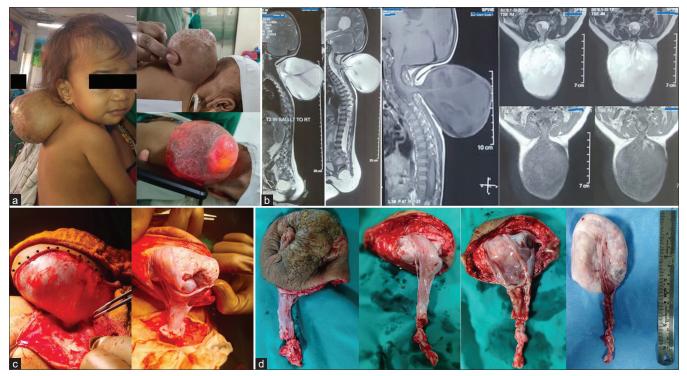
(a) A solitary saccular swelling over the cervico-dorsal region, (b) MRI was suggestive of a large cystic sac-like structure protruding posteriorly through the defect at C7-D1 level, (c) an elliptical incision was marked over the confluence of healthy and non-healthy skin, and (d) insertion of the fibroneural stalk inserting into the dorsal sac.
